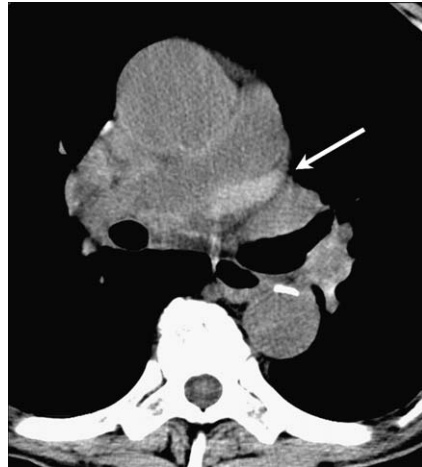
Mediastinal hematoma. In patients who have aortic rupture, the high attenuation of acute blood (*arrow*) is readily apparent within the mediastinum on unenhanced CT.
